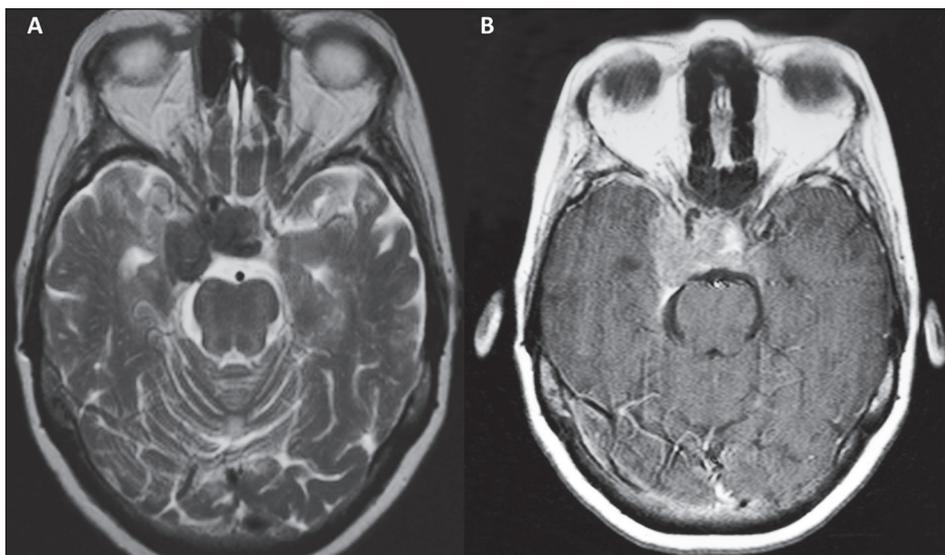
Magnetic resonance imaging scan showing a well-defined, compact, lobulated expansile lesion, measuring 3.0 × 1.5 × 3.0 cm, located in the right sellar and juxtaseilar region, invading and occupying the sella turcica and the right juxtaseilar region, with a hypointense signal on a T2-weighted image (A) and intense enhancement on a T1-weighted image acquired after gadolinium contrast administration (B). Note the reduction in the caliber of the intracavernous carotid arteries. The lesion is compressing and displacing the optic chiasm anteriorly, cavitating the right medial temporal region, surrounding the pituitary gland, and extending to the supra-sellar cistern. Anteriorly, it reaches the right optic canal.
